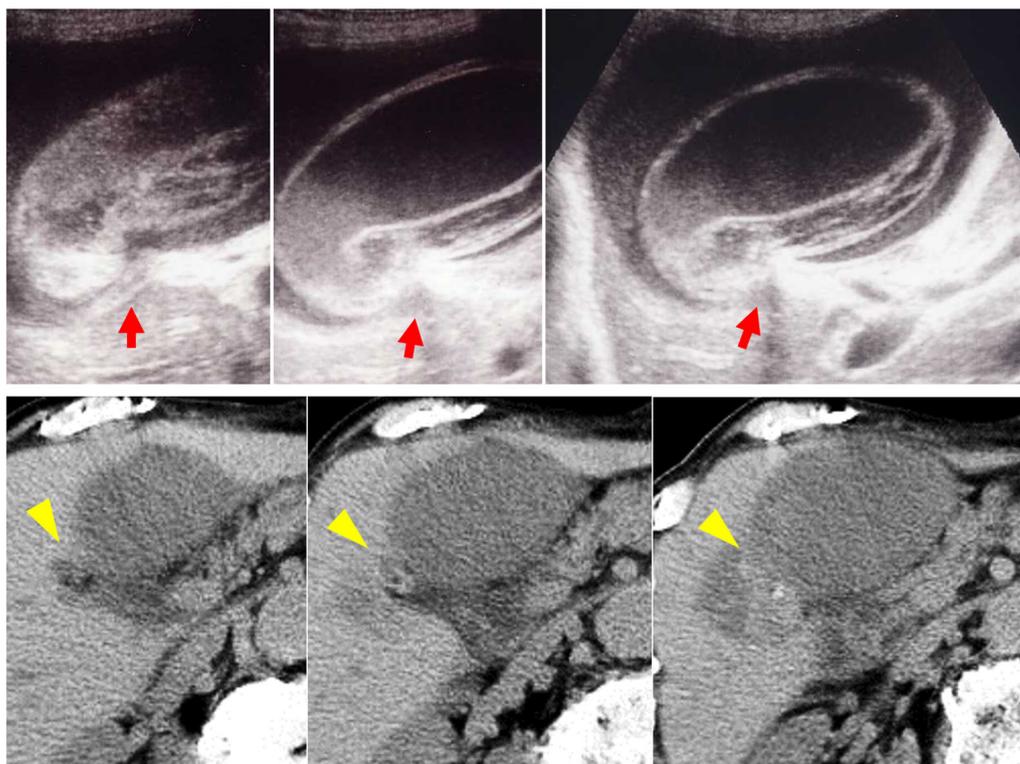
US and CT findings; US images showing twisting of the cystic duct and traction of hepatoduodenal ligament (upper series), and CT images showing a swollen gallbladder and its fundus was displaced below the midline (lower series)
